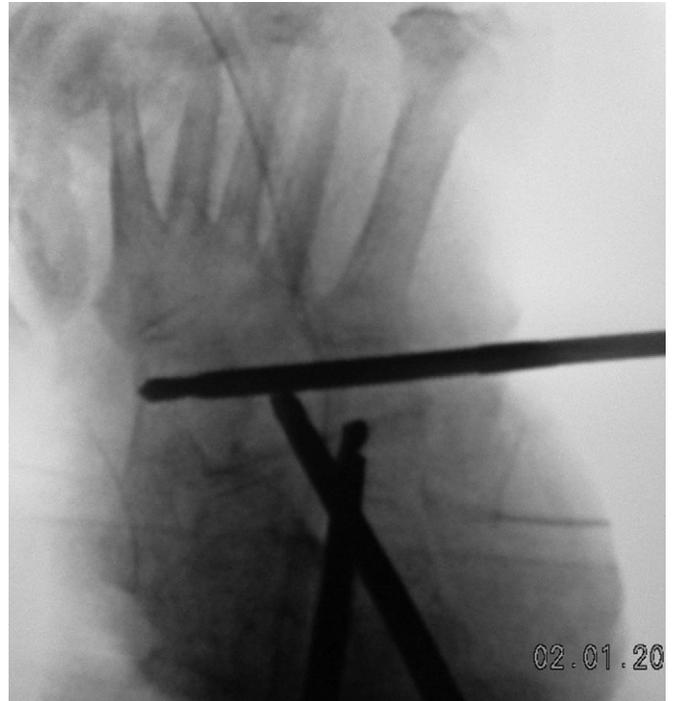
Anteroposterior and lateral intraoperative radiographs demonstrating the converging 5.5-mm pins, using the entire length of the calcaneus providing stabilization, leverage, and control of the hindfoot.
